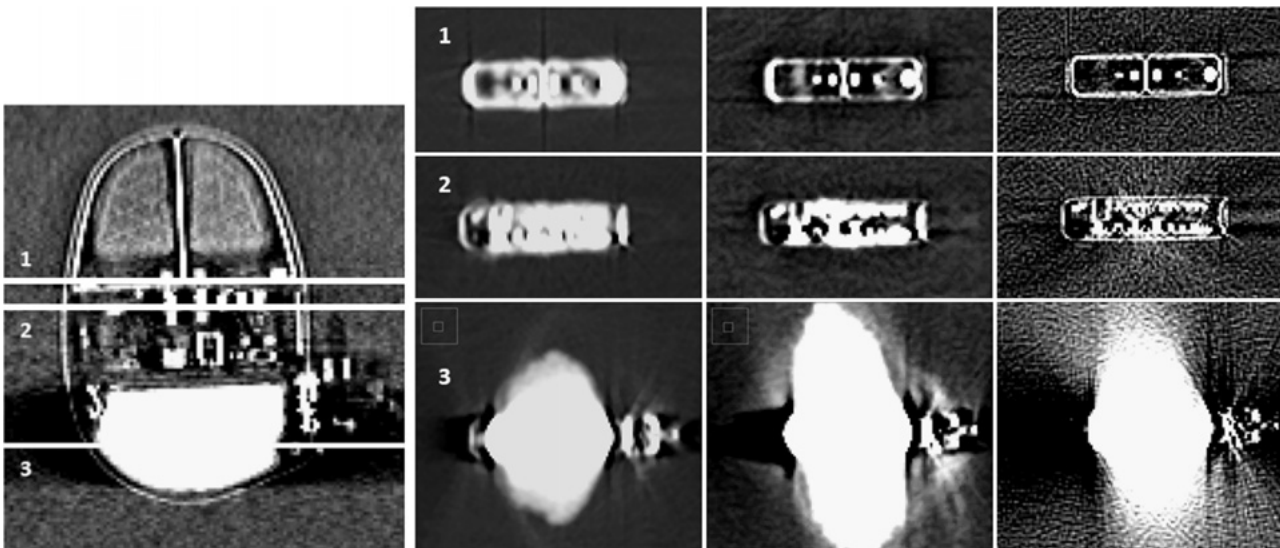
On the left the coronal view of the IPG is shown. The horizontal lines, labeled with 1, 2, 3, represent the position of the CT slices shown to the right of the coronal view. The CT slices are arranged in three columns corresponding to the CHU range (left column), the EHU range with MAR (middle column) and EHU range without MAR (right column).
